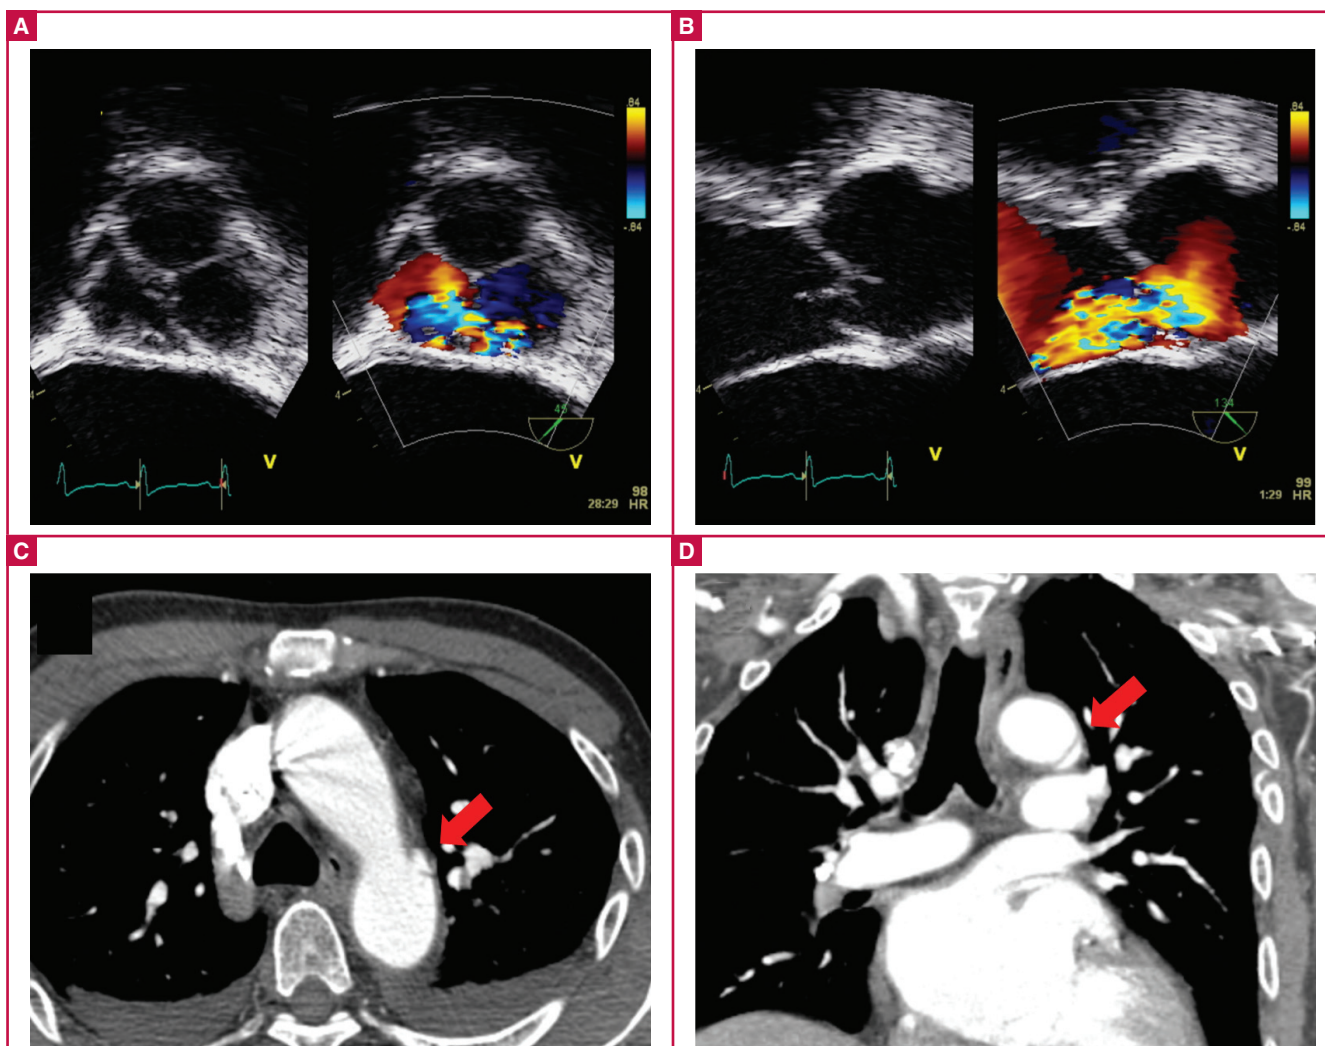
Aortic regurgitation shown in transoesophageal echocardiography and pseudo-aneurysm seen in computed tomography. (A) In the short-axis view, a tear of the non-coronary cusp was suspected, and in the short-axis view with colour Doppler, significant severe aortic regurgitation in the region of the non-coronary cusp was seen. (B) A long-axis view revealed rupture of non-coronary cusp with torn linear tissue, and in the long-axis view with colour Doppler, severe aortic regurgitation with rupture of the non-coronary cusp was seen. (C) In a post-enhanced axial view, a small pseudo-aneurysm (arrow) in the aortic isthmus is demonstrated. (D) A coronal reformatted image revealed a small pseudo-aneurysm (arrow) at the level of the proximal descending thoracic aorta.
